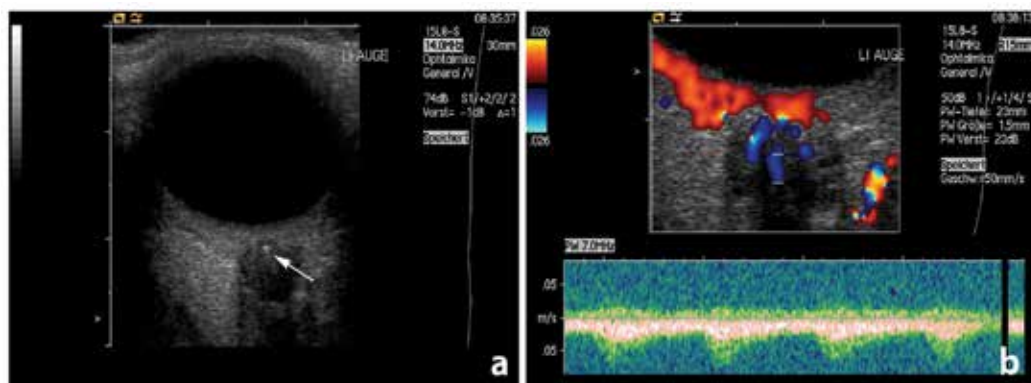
Ultrasound findings in a patient with embolic central retinal artery occlusion. (a) B-mode: Hyperechogenic „spot sign“ in the optic nerve head (arrow), representing an embolus in the distal CRA. (b) Color-Duplex- and spectral Doppler-mode: absent flow in the CRA with persistent perfusion of the central retinal vein
